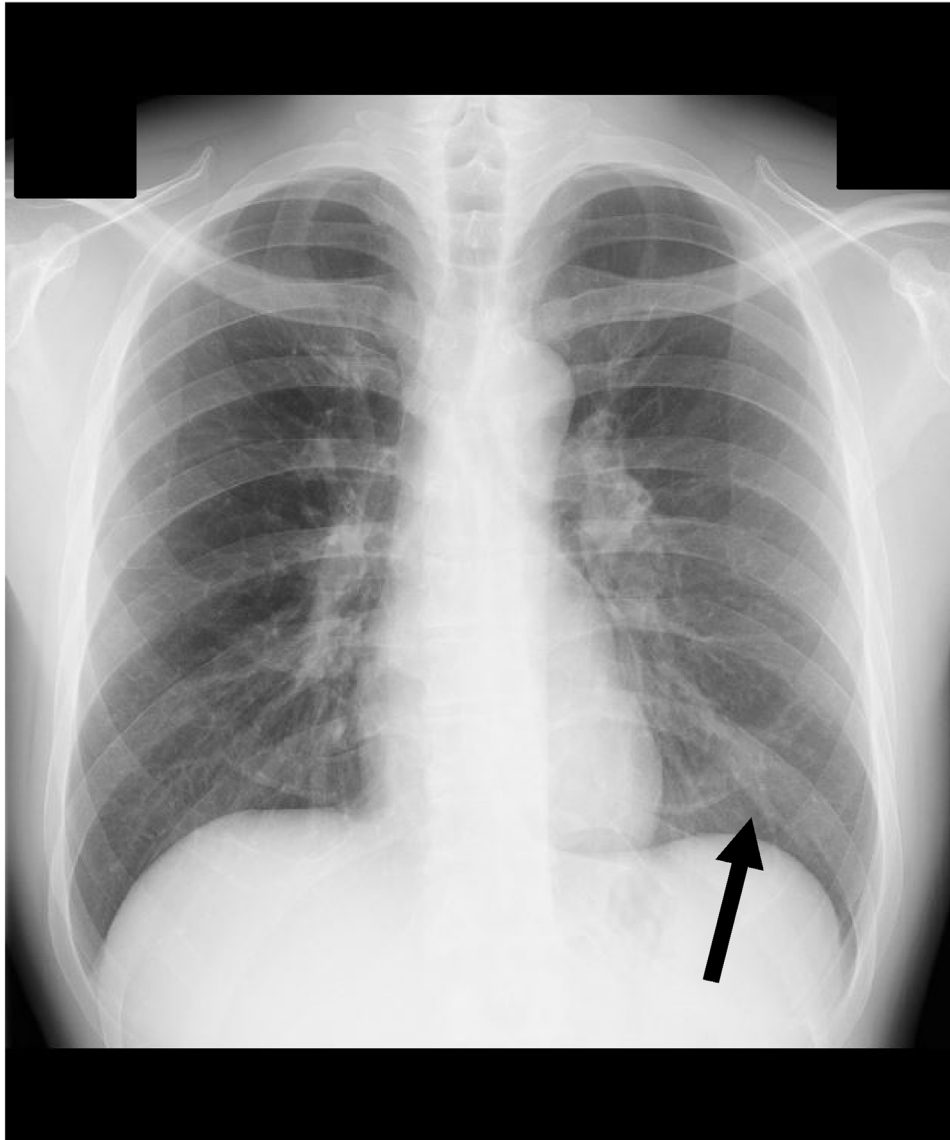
Chest X-ray findings of patient 1. Slight bronchiolitis is evident in left lower lung (arrow).
